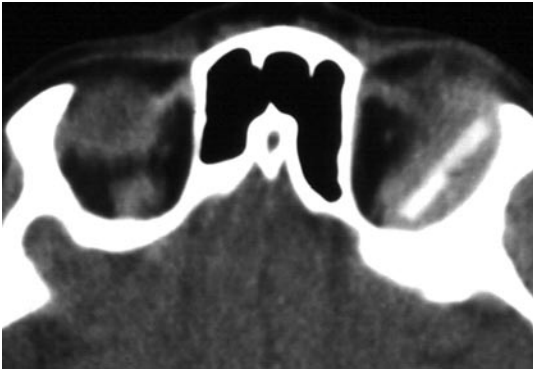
CT image of an orbital FB. The hyperdense object (windshield glass fragment) in the left orbit measures 2×2×20 mm on the scan (Courtesy of A. Palkó, Szeged, Hungary)
